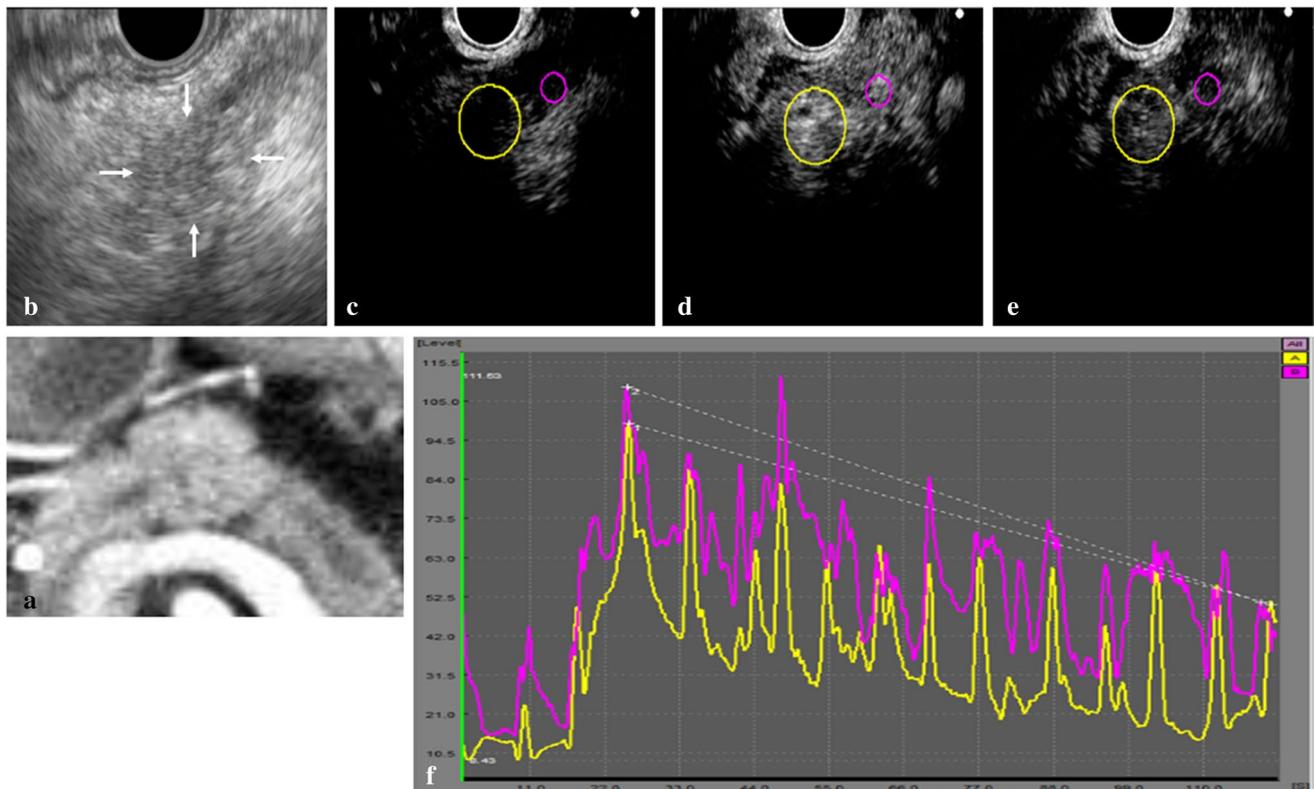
A pancreatic endocrine tumor in the G3/NEC group within the pancreatic body. a Contrast-enhanced computed tomography image. b Fundamental B-mode endoscopic ultrasonography (EUS) showed a hypoechoic lesion. c A pre-enhancement image. d EUS image at the peak of contrast enhancement. The yellow and purple circles show the regions of interest (ROIs) in the tumor and pancreatic parenchyma, respectively, both of which were enhanced. e EUS image obtained 120 s after Sonazoid injection, revealing continued
